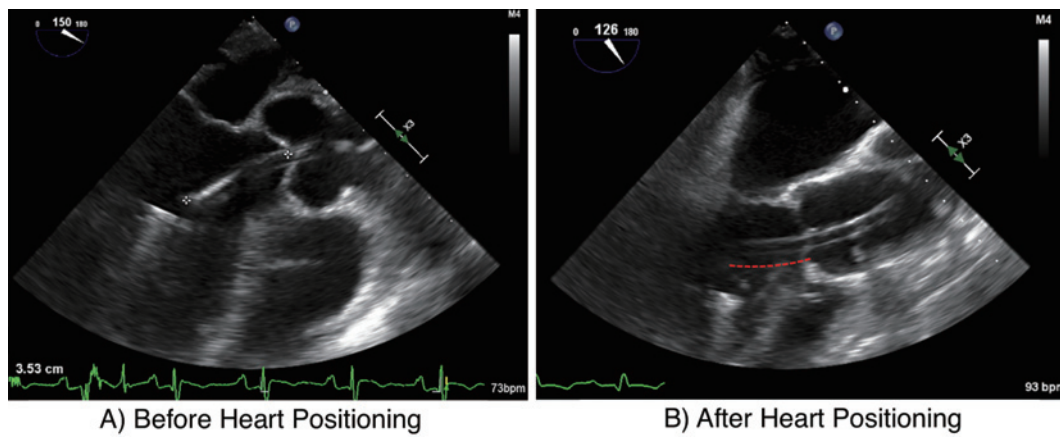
Transthoracic echocardiography of Impella positioning in Case 2
